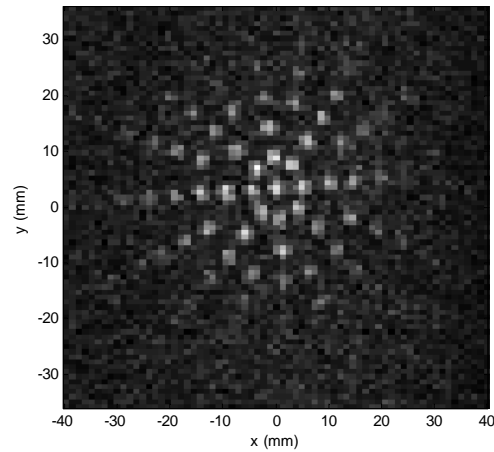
ULF MRI measured for  $CuSO_4$  doped de-ionized water.  $T_2$  was  $\sim 150$  ms. The image is an average of 10 scans.
